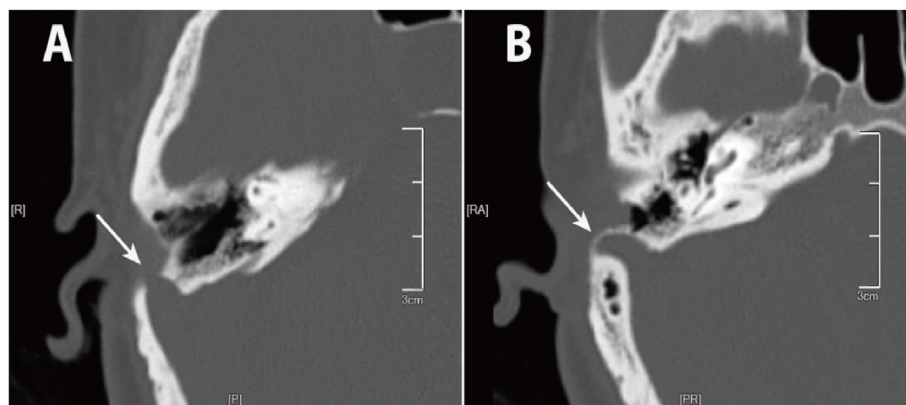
Postoperative review of the CTA images of the study patients (arrow). A: Patient A was re-examined on CTA in the 8th month after surgery, and the surface of the original bony defect of the sigmoid sinus was covered by a soft tissue with no communication with the mastoid airspace. B: Patient B was re-examined in the 15th month after surgery and CTA showed no bony defects in the sigmoid sinus with the surface covered by soft tissues.
